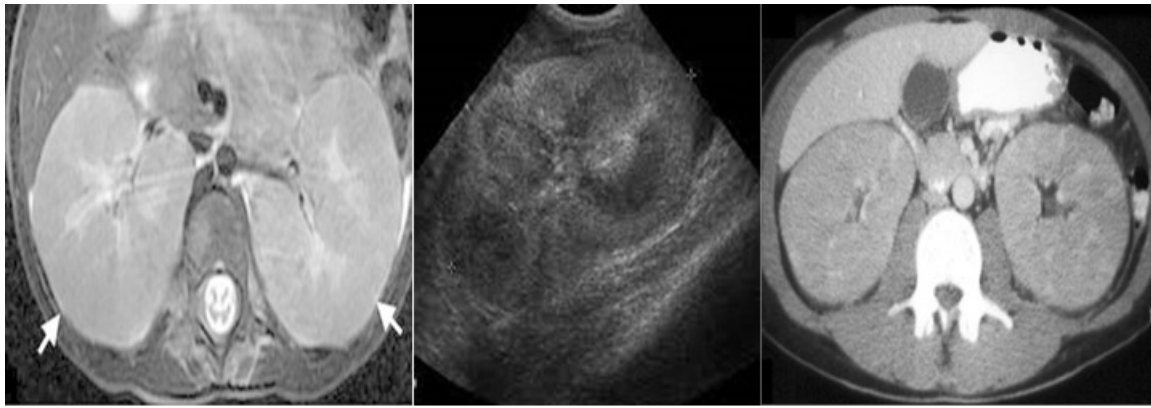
(A) axial MRI image shows enlarged both kidneys with multifocal cortical lesions, (B) Ultrasound shows an enlarged right kidney with cortical homogenous hypoechoic lesions. (C) Axial CT scan shows an enlarged, edematous kidney with cortical enhanced low-density lesions.
